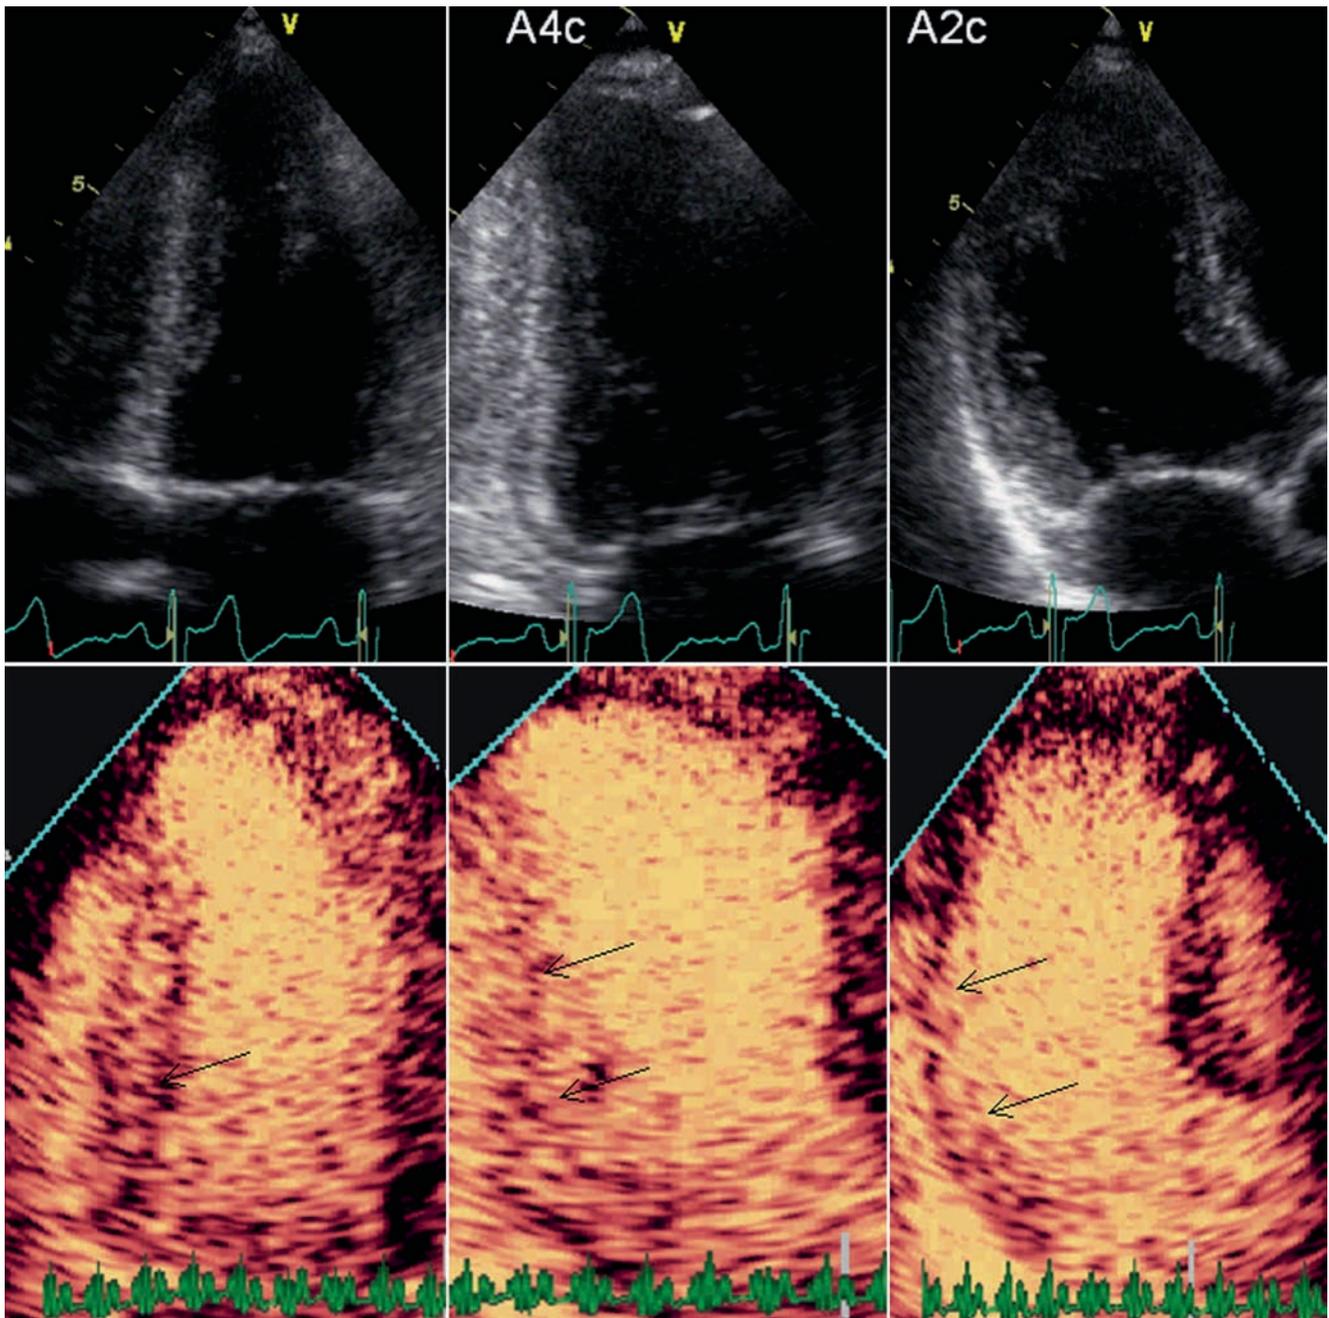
Resting and myocardial contrast echocardiography in a 65-year-old man after late presentation MI. Despite regional wall motion abnormalities in the inferior wall, perfusion is preserved, (myocardial contrast marked by arrows) suggesting viability
